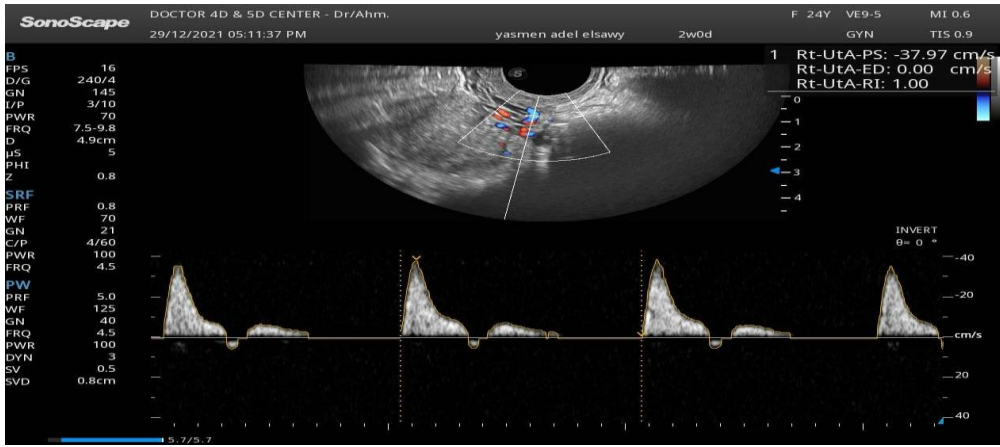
Uterine artery Doppler results of case who get pregnant after ICSI.
